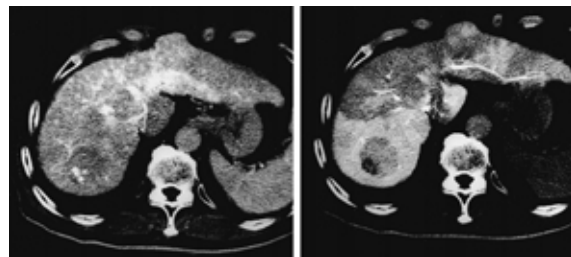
Case 6. CTA (left side) and CTAP (right side)
